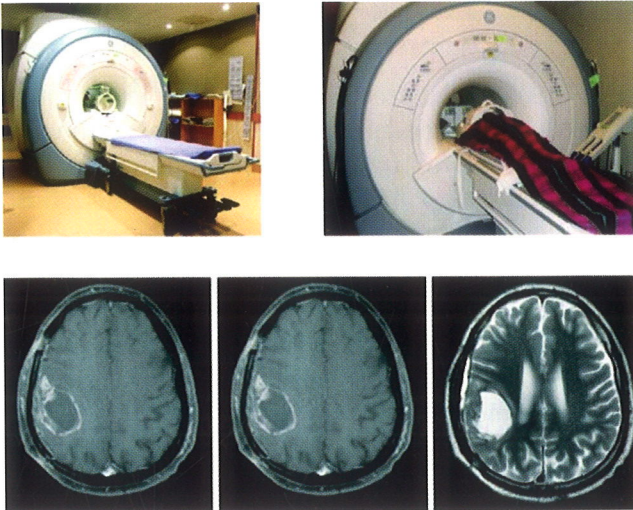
Various sequences of MRI showing a clear picture of brain tumour
